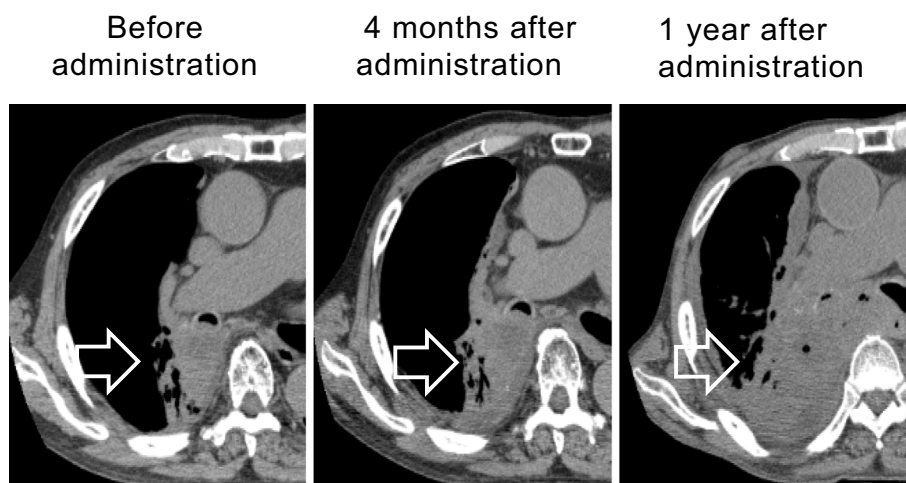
Plain computed tomography (CT) scanning of lung cancer (primary lesion). Three time points of CT scanning for lung cancer are shown. The arrow indicates the main tumor in the right S6 lesion extending to the right main bronchus. The primary lesion was stable until four months after starting nivolumab administration (two months after the discontinuation of nivolumab administration). One year after starting treatment, the tumor was judged to be progressive disease.
